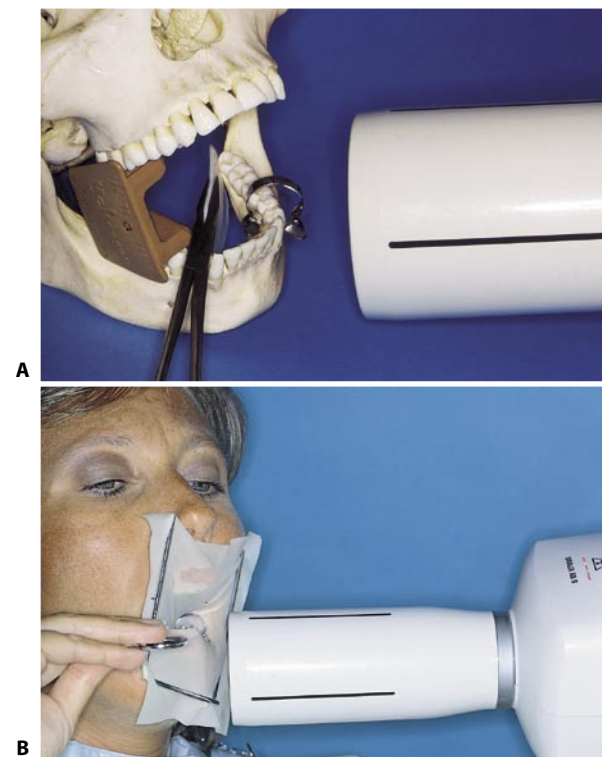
Intraoperative radiograph of the lower premolars. A. The film is positioned horizontally. B. The patient rests the forceps on the contralateral teeth.
